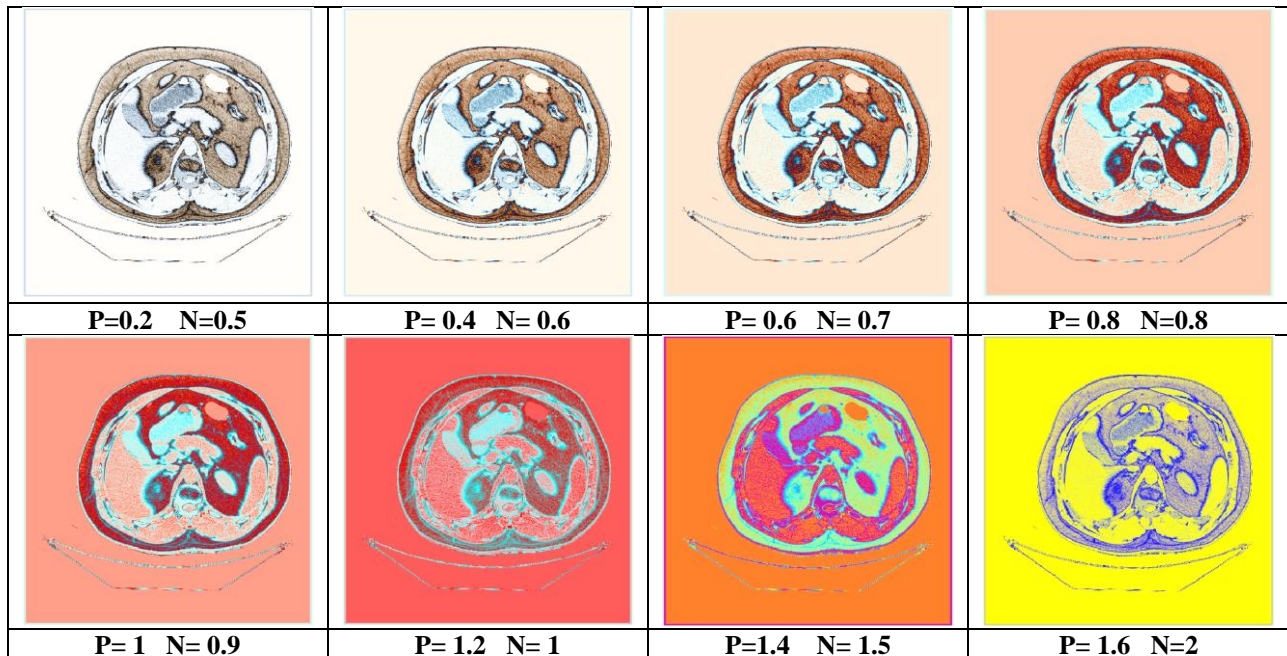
The color output CT-Scan images with different P and N values
